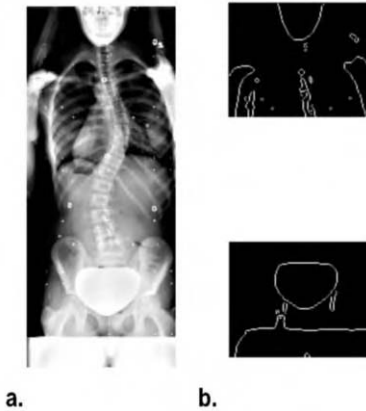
(a) Postero-anterior radiograph of a patient diagnosed with AIS (b) Global features detection
